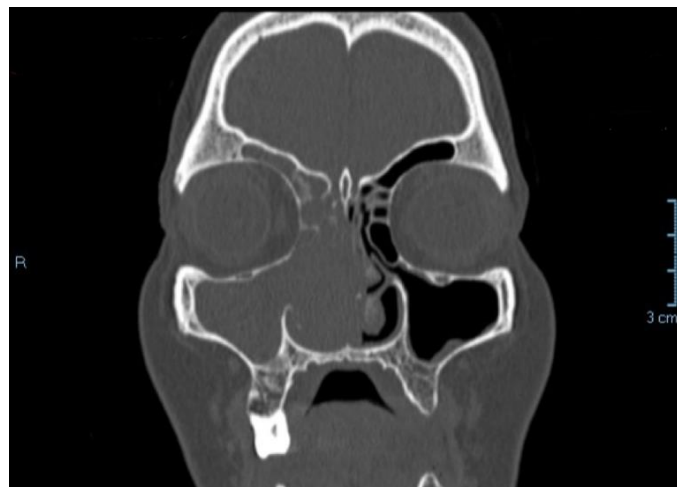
& 3 (CT PNS showed complete opacification of right-side ethmoidal air cells associated with an increased mucosal wall thickness of the right maxillary and right sphenoidal sinus)
